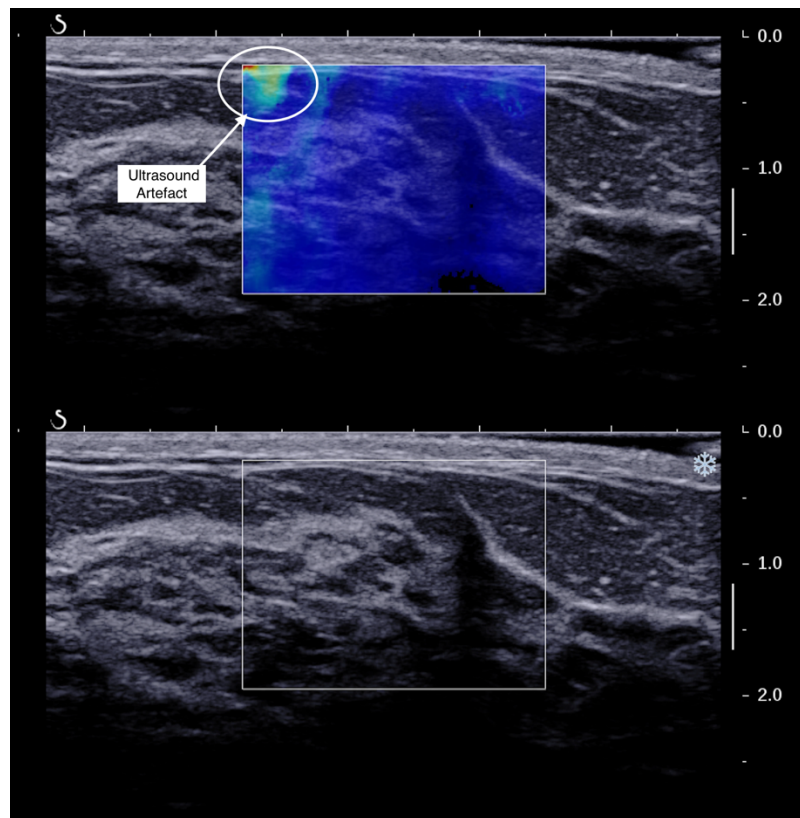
Shear wave Elastography image with Ultrasound artefact highlighted
